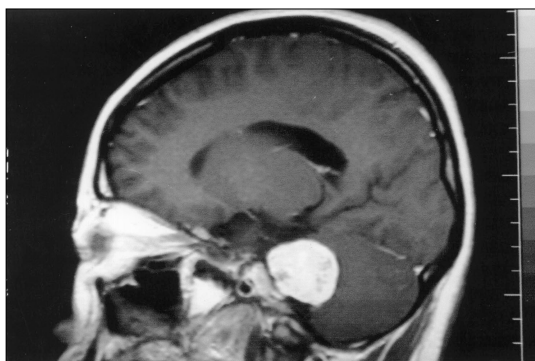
MRI of brain (Sagittal T1 image) after gadolinium showing a large tumor consistent with an acoustic neuroma.
